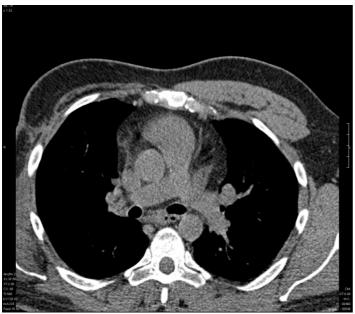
Breath-hold CT of Patient 3
